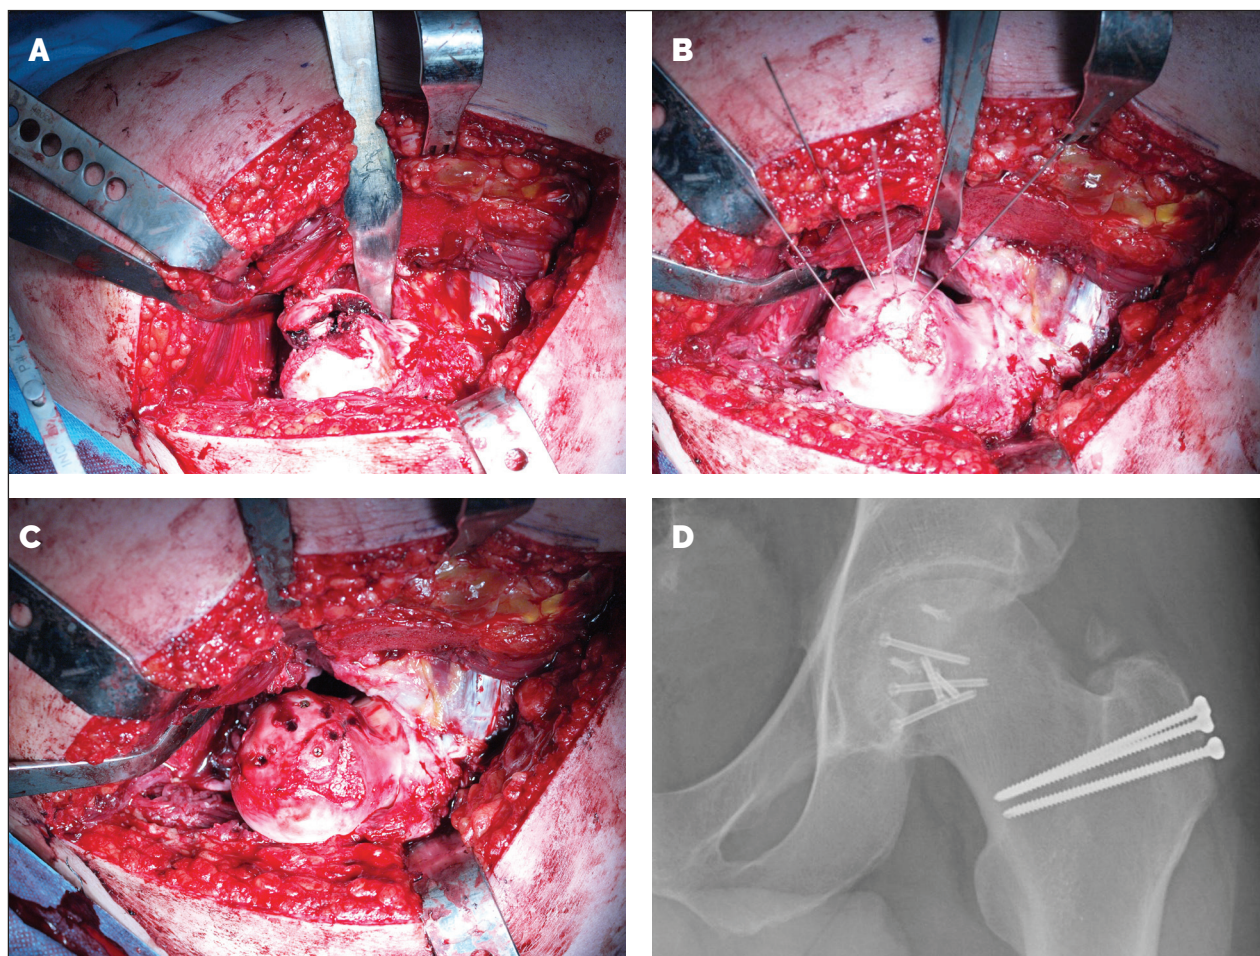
intraoperative view of Pipkin type I fracture before reduction (A), after the achieved reduction is held by k-wires (B), after final fixation (C) and Xrays at two years follow-up (D).
